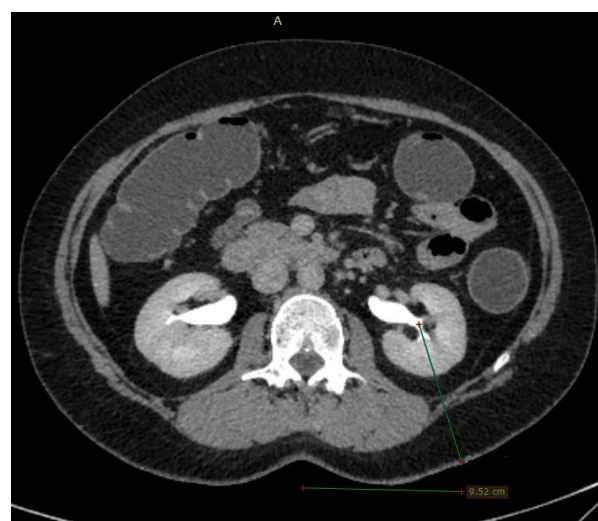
Measurement of lateral projection of the long axis of the postero-inferior calix, calculated on axial sections of CT scan.
